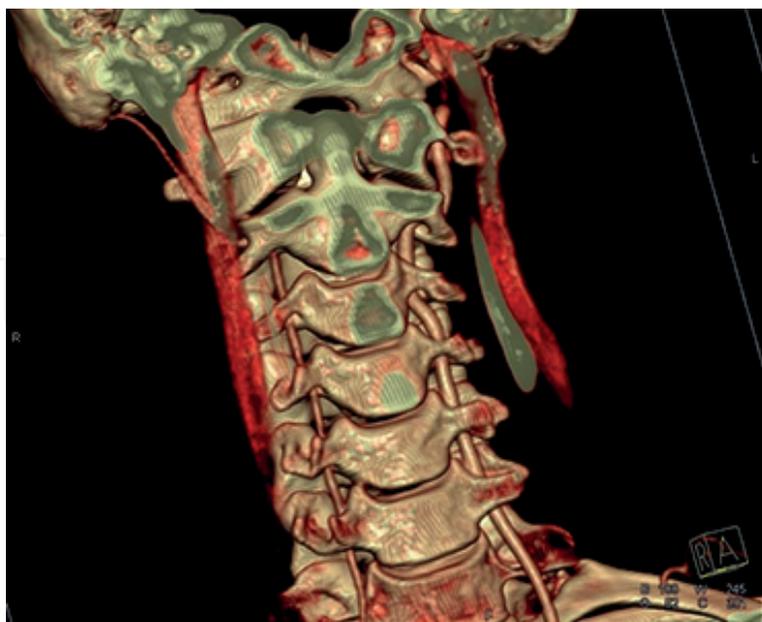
Angio-CT of the vertebrobasilar system vascular anomaly in the male patient. Asymmetry of the diameter of the vertebral arteries with the dominant left spinal artery.
